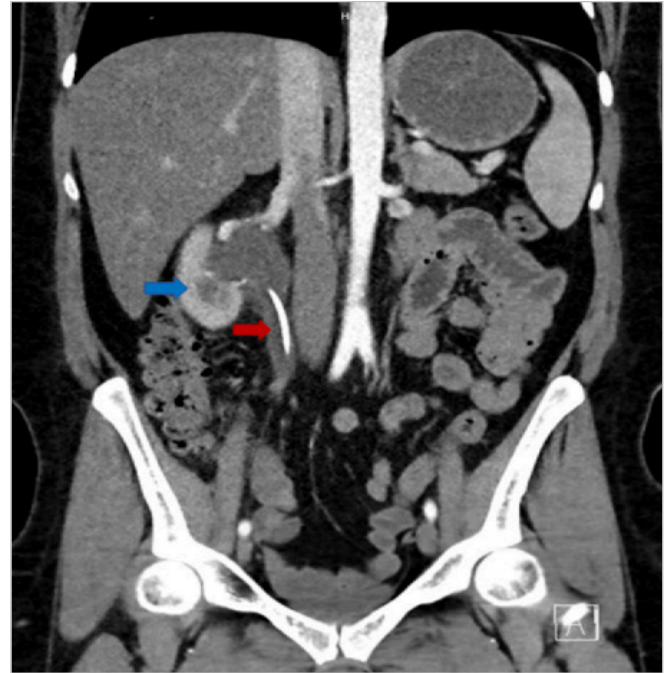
Coronal contrast-enhanced CT scan of the abdomen and pelvis demonstrating right-sided moderate to severe hydronephrosis (blue arrow), and dilation of the proximal right ureter (red arrow).
